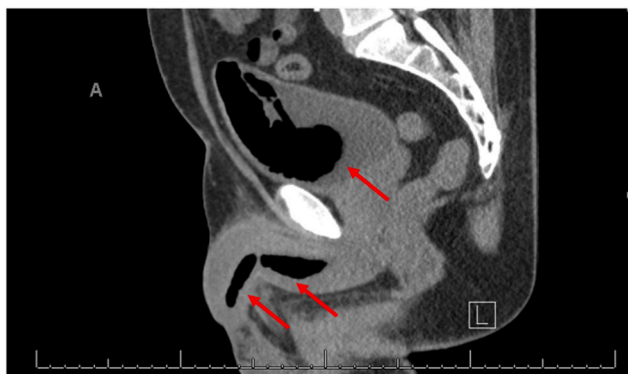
CT Scan: Arrows point to spray foam within the urinary tract.
